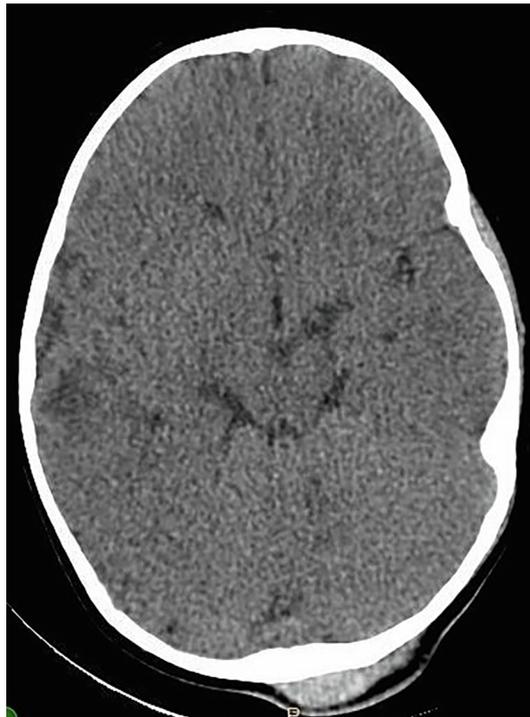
Pre-operative axial view of a CT Head depicting the subcutaneous lesion of the posterior scalp (soft tissue window).
